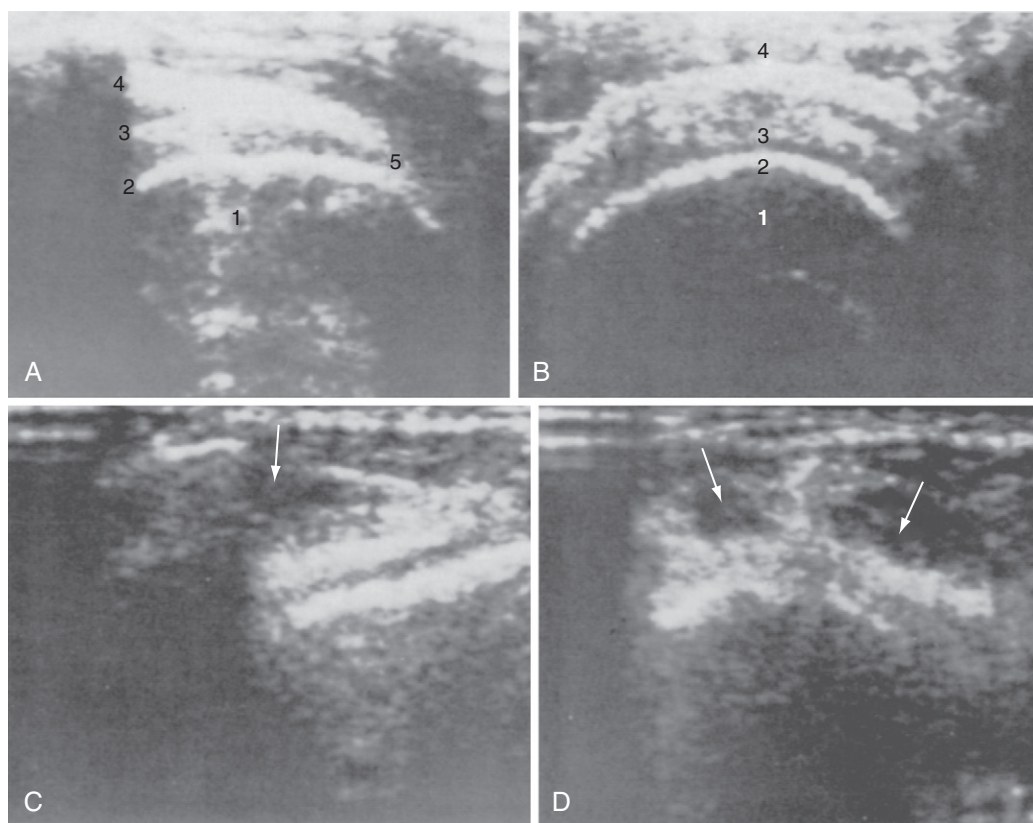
A, Normal longitudinal view of rotator cuff by ultrasound shows the humeral head (1), the superior articular surface (2), the rotator cuff (3), the deltoid tendon (4), and tapering of the cuff to its insertion on the greater tuberosity (5). B, Transverse view of a normal intact rotator cuff covering the humeral head. C, Rotator cuff tear, showing a hypoechoic area (arrow) on a longitudinal view. D, Rotator cuff tear, showing hypoechoic area (arrows) on a transverse view.
